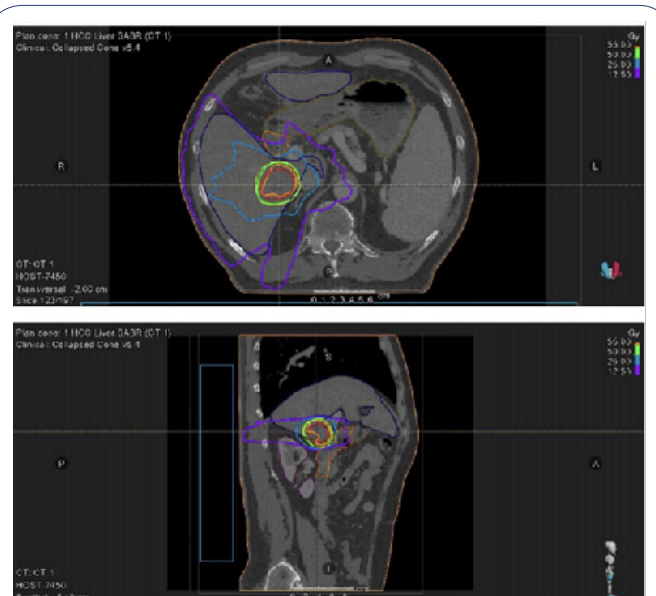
SABR planning CT abdomen and pelvis. Transverse view above, sagittal view below. In red, the planning target volume (obtained by adding an 8mm superior and 6mm margin in all other planes to the GTV) receiving maximum dose of 55 Gy.
